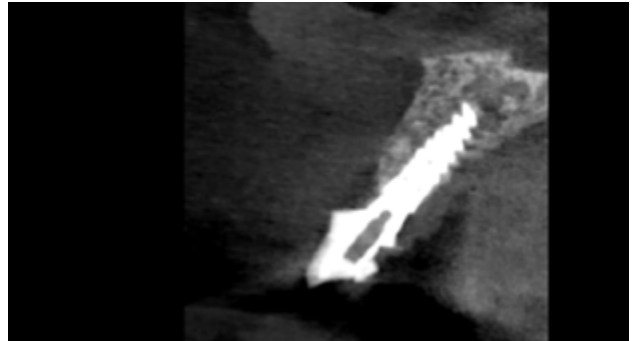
Study with CBCT to assess the condition of bone tissue. No evidence is seen of pathological signs or alterations related to treatment failure.
